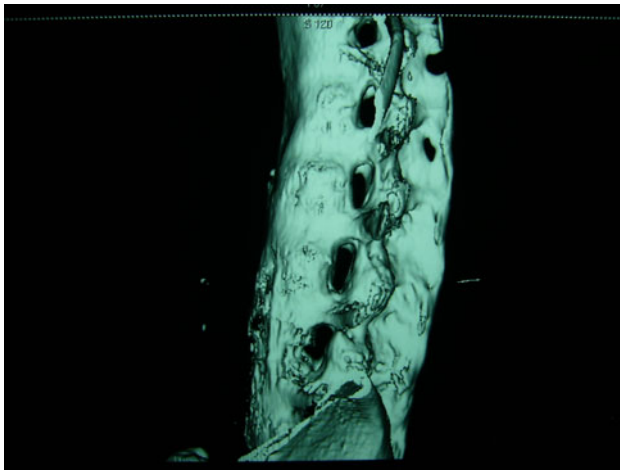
A 3-D reconstruction CT scan shows a completely ossified ligamentum flavum.
